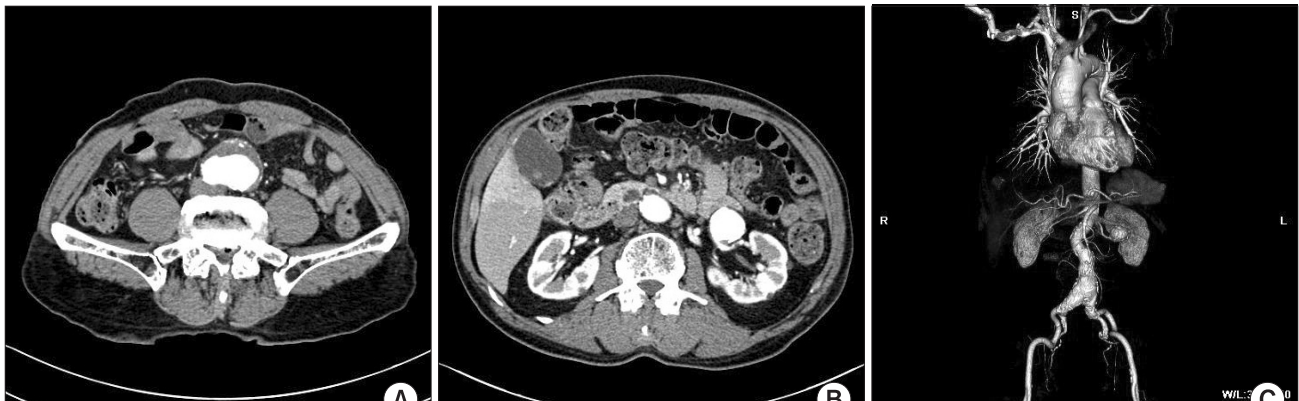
Preoperative contrast enhanced computed tomography scan with 3-dimensional reconstruction showed abdominal aortic aneurysm (A) and renal artery aneurysm (B) in the left renal artery in axial and three dimensional reconstruction (C).
